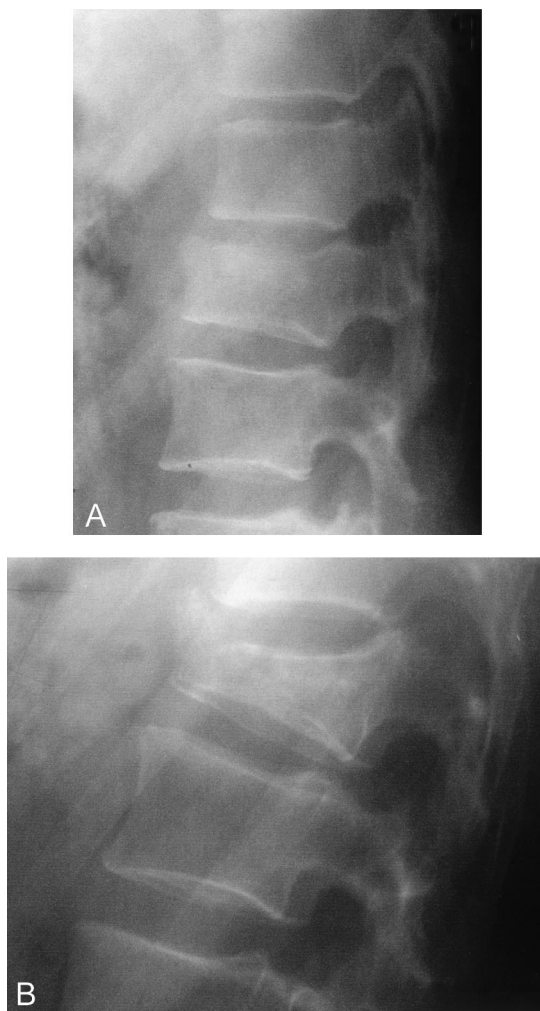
A, B: A 44-year-old man fell off a scaffolding and sustained a wedge fracture of L1. The supine Cobb angle of 16° increased to 22° on erect radiographs. The vertebral body compression increased from 22% to 65%.
